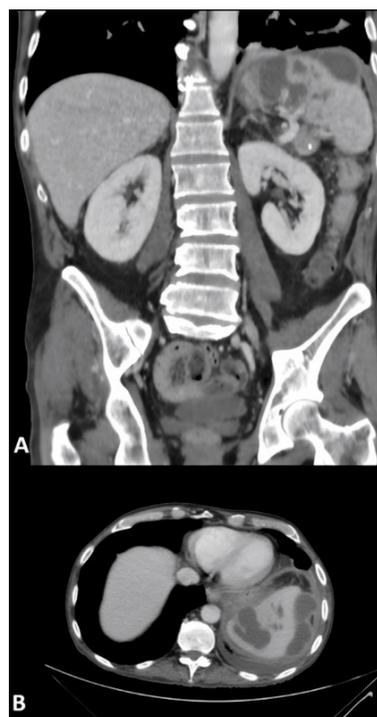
Splenic lesions observed on CT scan.
